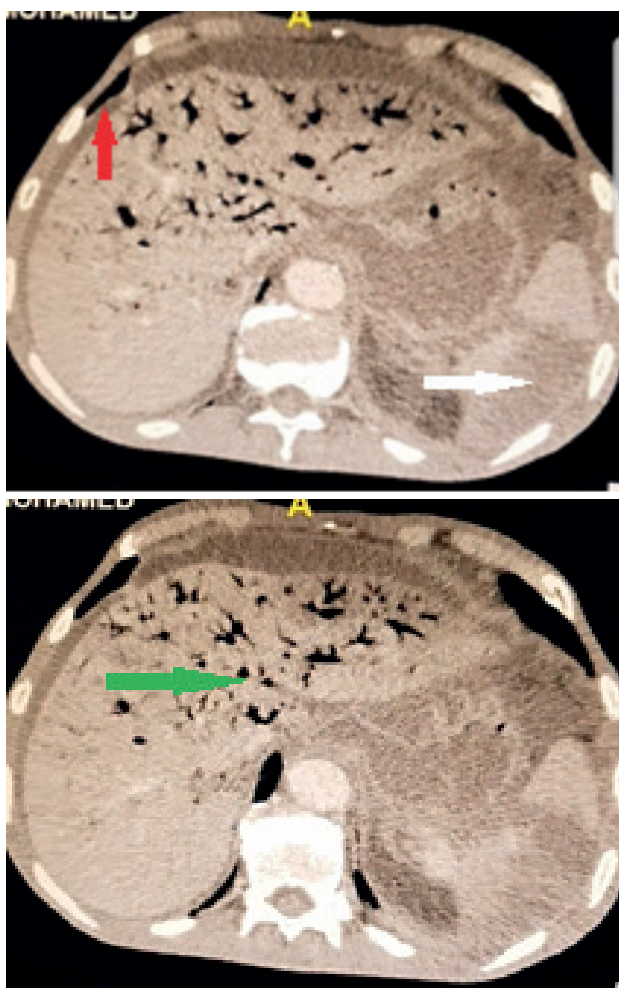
Computed Tomography scan of the abdomen axshowing free intraperitoneal fluid with splenic abscess (white arrow), pneumopertoneum (red arrow) and major aeroportia (green arrow).
